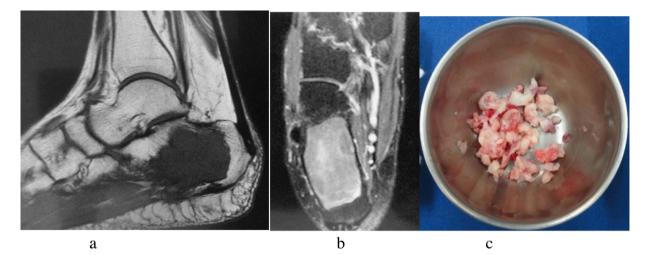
Fibrous dysplasia. MRI T1W (a) shows a well-defined hypo-intense lesion in calcaneus with homogeneous enhancement on fat suppressed T1W post contrast imaging (b). Appearance of post-surgical curettage material (c).
